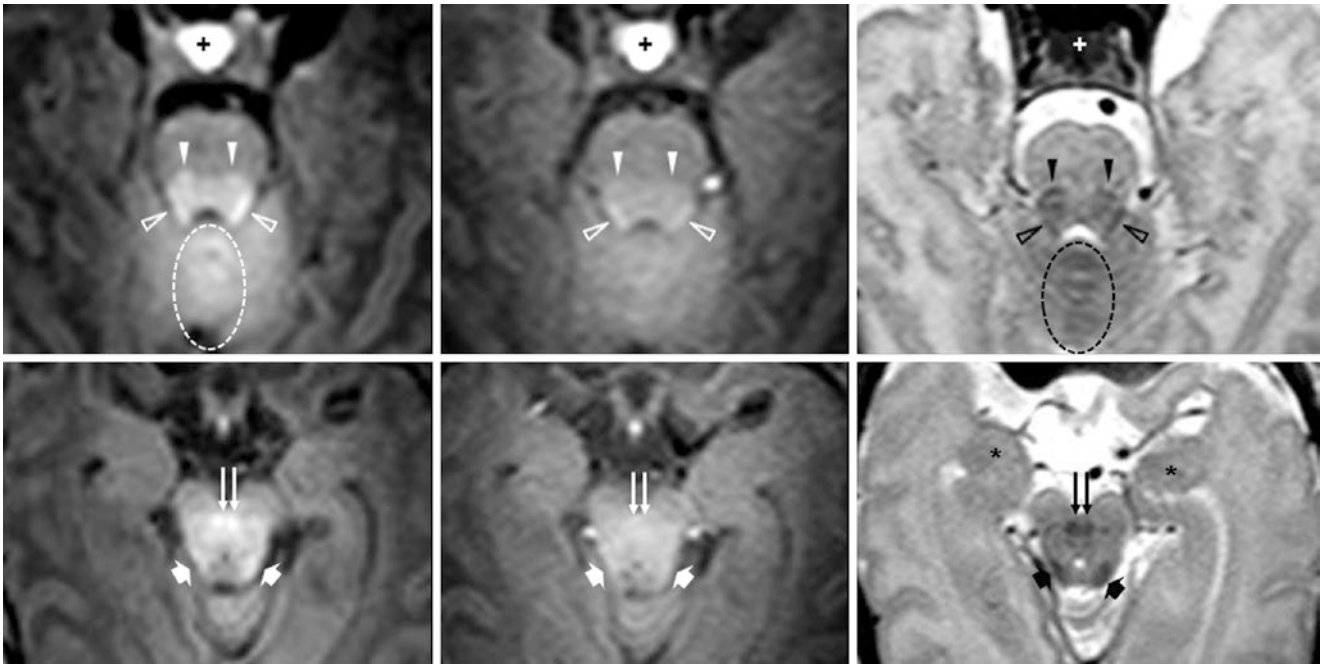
A 7-day-old term neonate had a 3T MRI with GE T1WI (left column) and SE T2WI (right column), on which both the BIC (wide arrows) and the DSCP (double arrows) should be visible in all term neonates, but are not well seen on SE T1WI (middle column).
